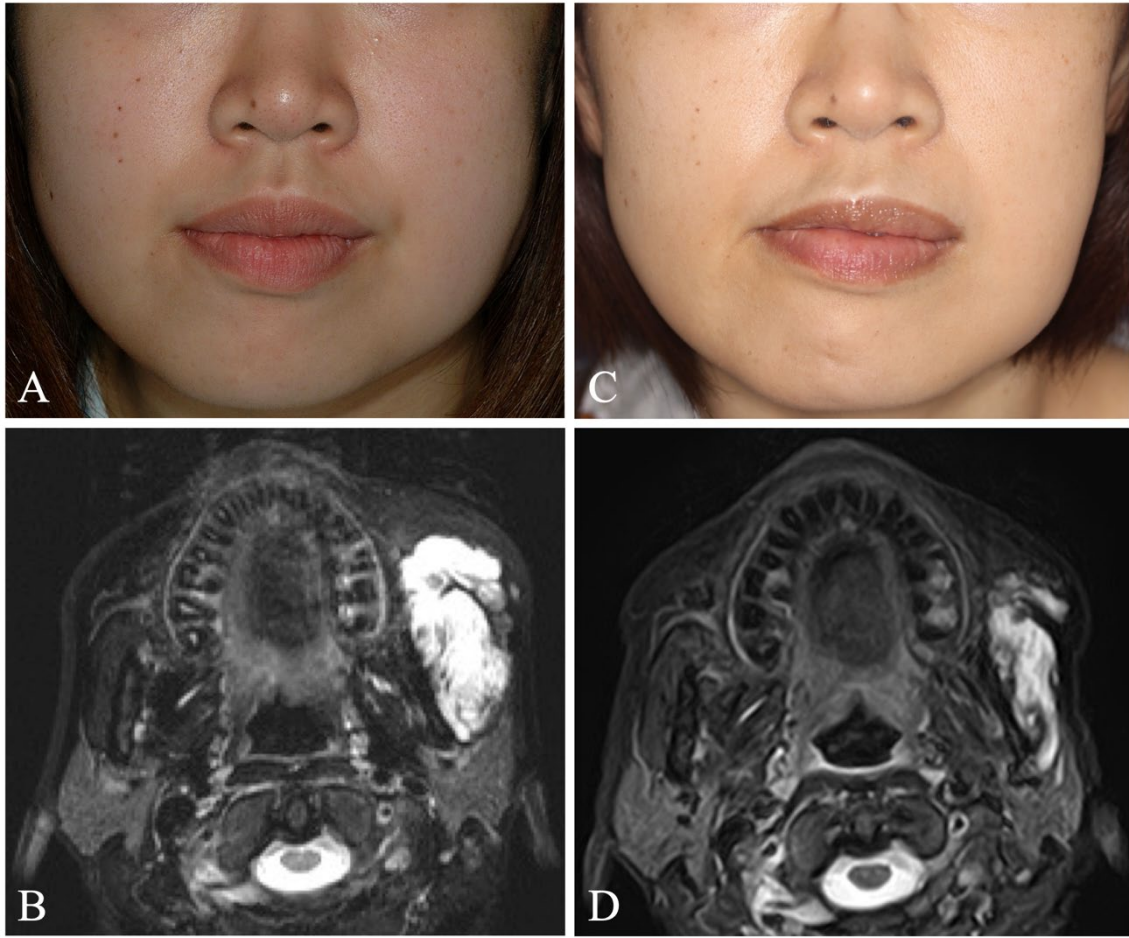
Patient 7 showed fair effectiveness of treatment. (A) Initial clinical photograph and (B) fat-suppressed T2-weighted magnetic resonance image of a 26-year-old woman with venous malformation in the left cheek. Sclerotherapy was started at the age of 26 years and consisted of 1 session of ethanol sclerotherapy followed by 30 sessions of polidocanol 1%–3% sclerotherapy. Persistent facial nerve paralysis of the temporal branch occurred at the first session of sclerotherapy, at which time 20 mL of ethanol was used. Since then, she has undergone sclerotherapy using polidocanol 1%–3% without any complications. (C) Clinical photograph and (D) short tau inversion recovery T2-weighted magnetic resonance image obtained at the age of 39 years after 31 sessions of sclerotherapy and a facelift. Although improvement of appearance was good, improvement of intralesional pain was fair.
